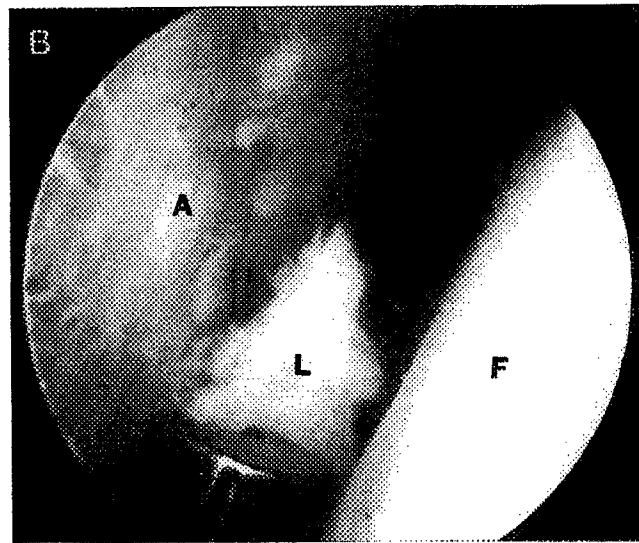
A 68-year-old man with recent onset of intractable right hip pain. (A) Anteroposterior (AP) radiograph is remarkable for moderate osteoarthritis. (B) Arthroscopic view of the right hip from the anterolateral portal. A large displaced fragment of labrum [L] posteriorly is being debrided. The femoral head [F] is on the right and the extent of underlying degenerative change is apparent in the acetabulum [A] on the left.
